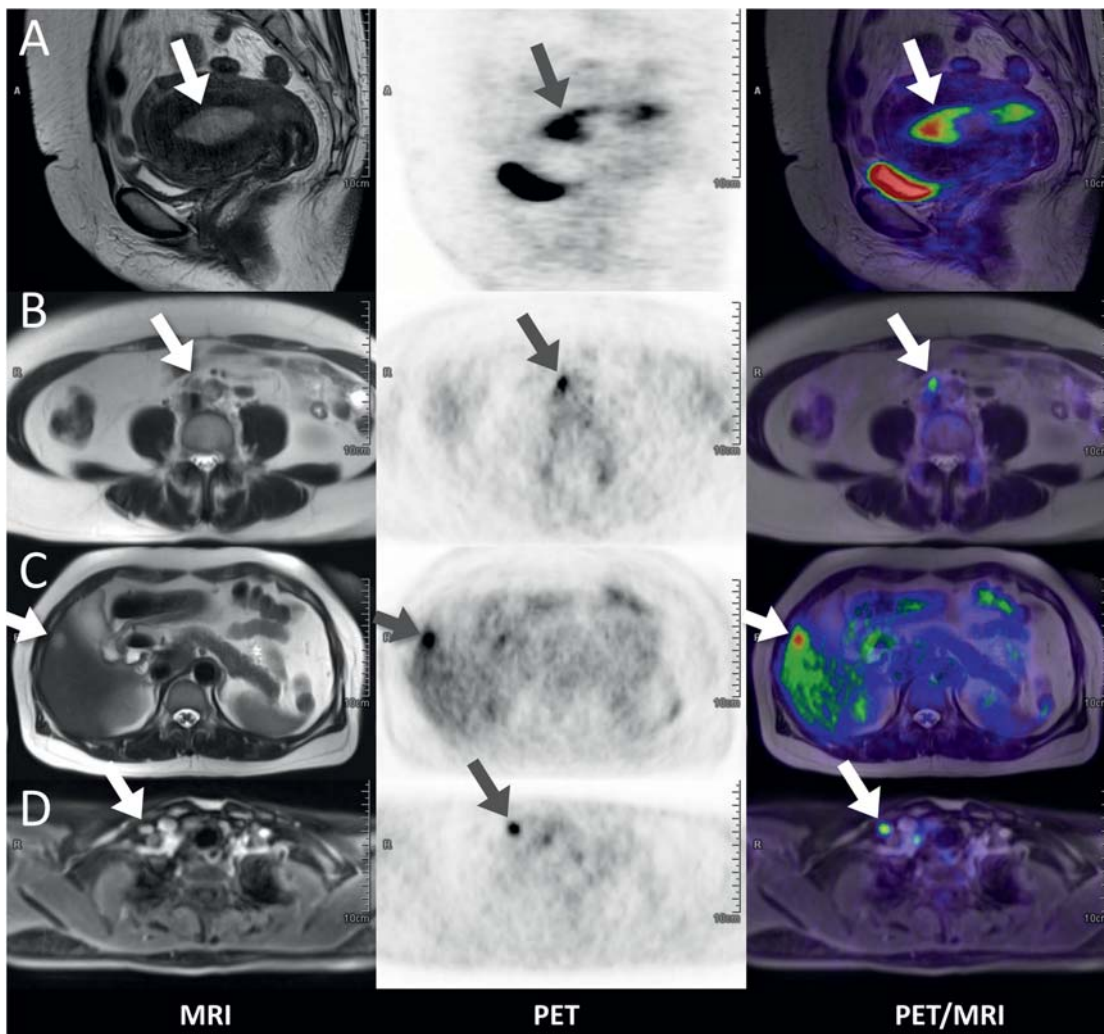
A 58-year-old woman with endometrial cancer, neuroendocrine carcinoma arising from carcinosarcoma, with multiple metastases, stage IVB. (A) MRI, PET, and PET/MRI showing hypermetabolic tumors (arrows) in the uterine cavity ($SUV_{max} = 25.2$). (B) A small FDG-avid lymph node in the aortocaval space. (C) A hepatic tumor in segment 5 with high FDG uptake, suggestive of metastasis. (D) Distant lymph node metastasis in the right supraclavicular fossa. The local staging and all of the metastases could easily be evaluated in a single PET/MRI examination.
